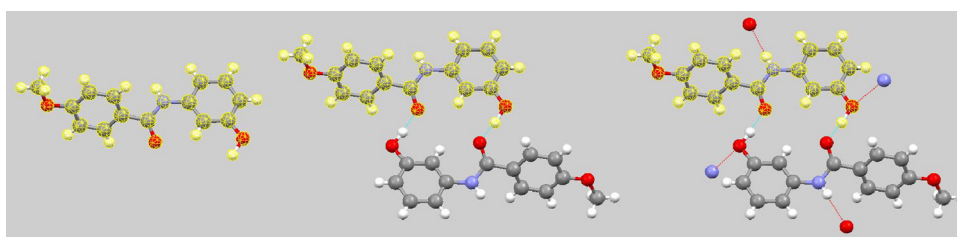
Monomer (a), dimer (b) and dimer with unit cell contacts (c) input models. Highlighted parts were compared with the experimental X-ray results.
